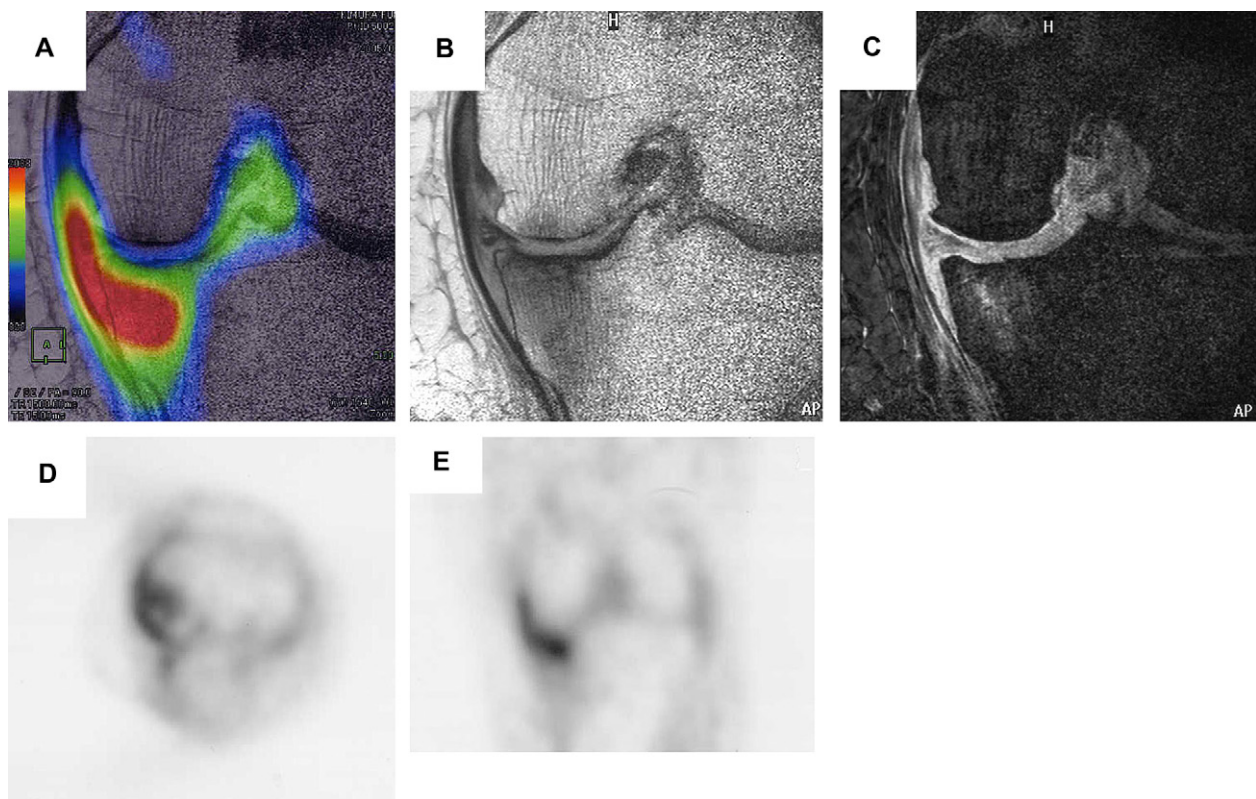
$^{18}\text{F}$ -FDG uptake was found in the bone marrow, spreading out into the medial soft tissue that was speculated to be synovium or ligament. (A) Fusion image, (B) proton density-weighted MRI, (C) fat-suppressed MRI, (D) PET axial view, and (E) PET coronal view.
